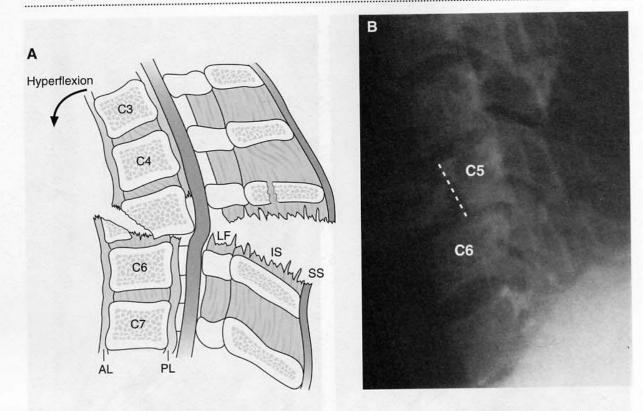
Teardrop hyperflexion injury. From a strictly anatomic perspective, hyperflexion of the cervical flexion will stretch or tear the posterior longitudinal ligament. (A) The injury has the following classic components (although variations occur, depending on the severity of the injury): avulsion fracture of a cervical (C5 shown) vertebral body ("teardrop body"), fracture of the spinous process, posterior subluxation of vertebrae, compression of the spinal cord, tear of the anterior longitudinal ligament (AL), and tear or disruption of the posterior longitudinal ligament (PL), ligamentum flavum (LF), interspinous ligament (IS), and supraspinous ligament (SS). (B) Lateral radiograph of a teardrop hyperflexion injury. Note the avulsion fracture of vertebral body C5 ("teardrop body"; dotted line) and the posterior subluxation of vertebra C5. (Adapted with permission from Levy RC, Hawkins H, Barsan WG: Radiology in Emergency Medicine. St. Louis, CV Mosby, 1986, p 78.)
